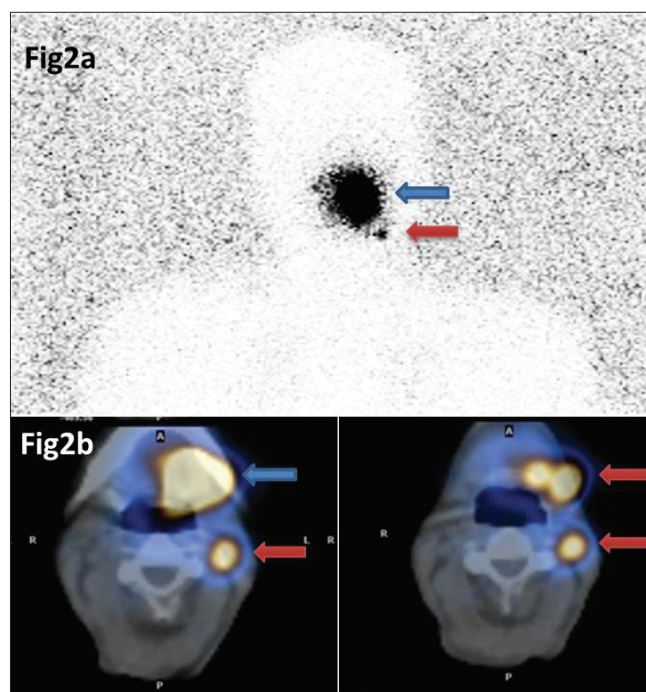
(a) shows a static flood source (using the ⁵⁷Co transmission source) image in the anterior projection showing injection site (blue arrow) and the single hotspot (red arrow). SPECT/CT of the same patient is shown in (b) showing the injection site (blue arrow) and three sentinel nodes (red arrows) at left cervical levels IB and II
